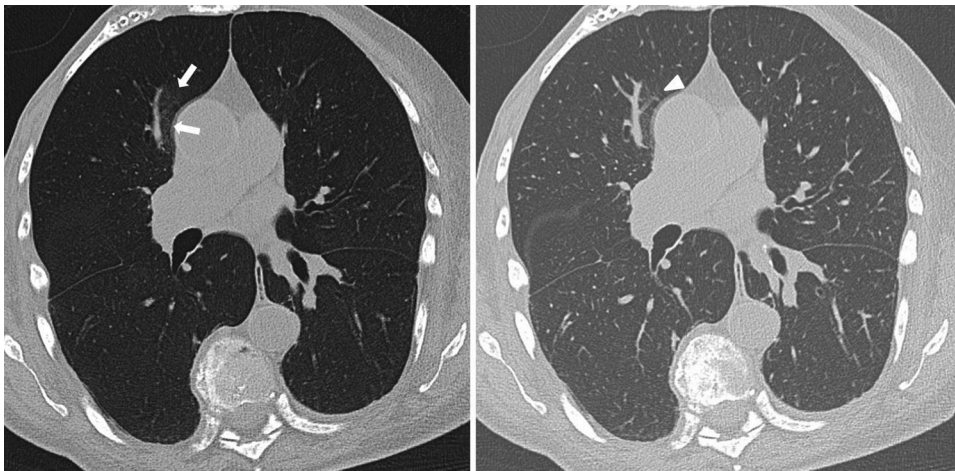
A 46-years-old woman presenting to the emergency department with fever and cough. The CT scan reveals subtle ground-glass opacity (GGO) (arrows) in the right paramediastinal upper lung lobe suspicious for early stage coronavirus disease 2019 (COVID-19) exclusively on axial minimum intensity projection (MinIP) reconstruction (left side). On axial standard multiplanar reformat (MPR) series (right side), the GGO was missed by 3/6 readers in this study due to a masking vessel (arrowhead).
